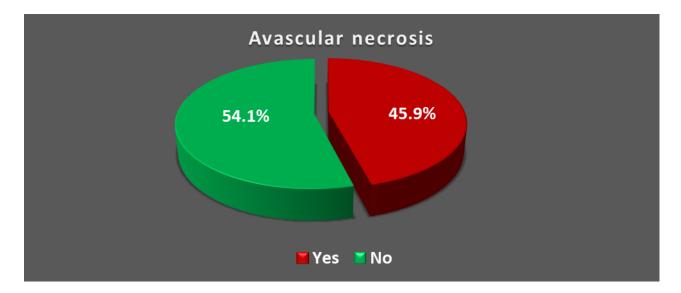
Distribution of the study patients according to final diagnosis of MRI
